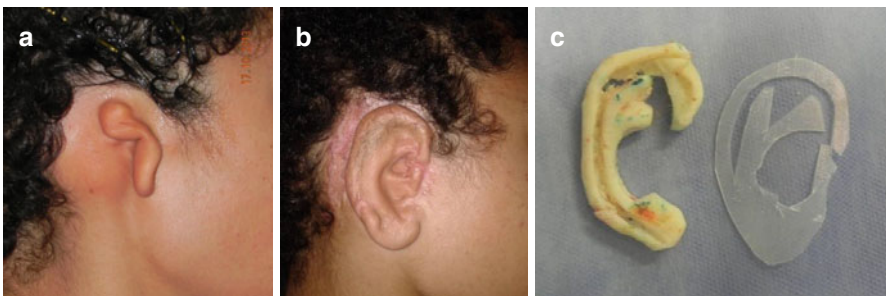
A 10-year-old boy with microtia on right side: (a) before surgery; (b) after two-stage reconstruction; (c) the auricular framework excavated on the rib cartilage beside the model in x-ray film
